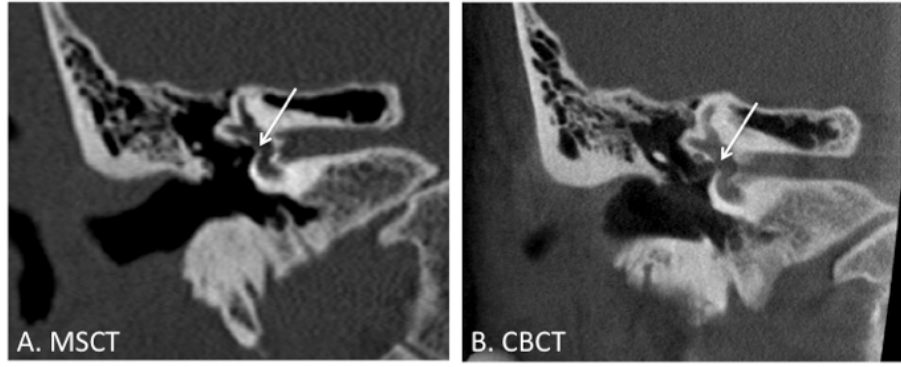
Frontal view. Normal oval window in the same patient visualized by MSCT (A) and CBCT (B).
